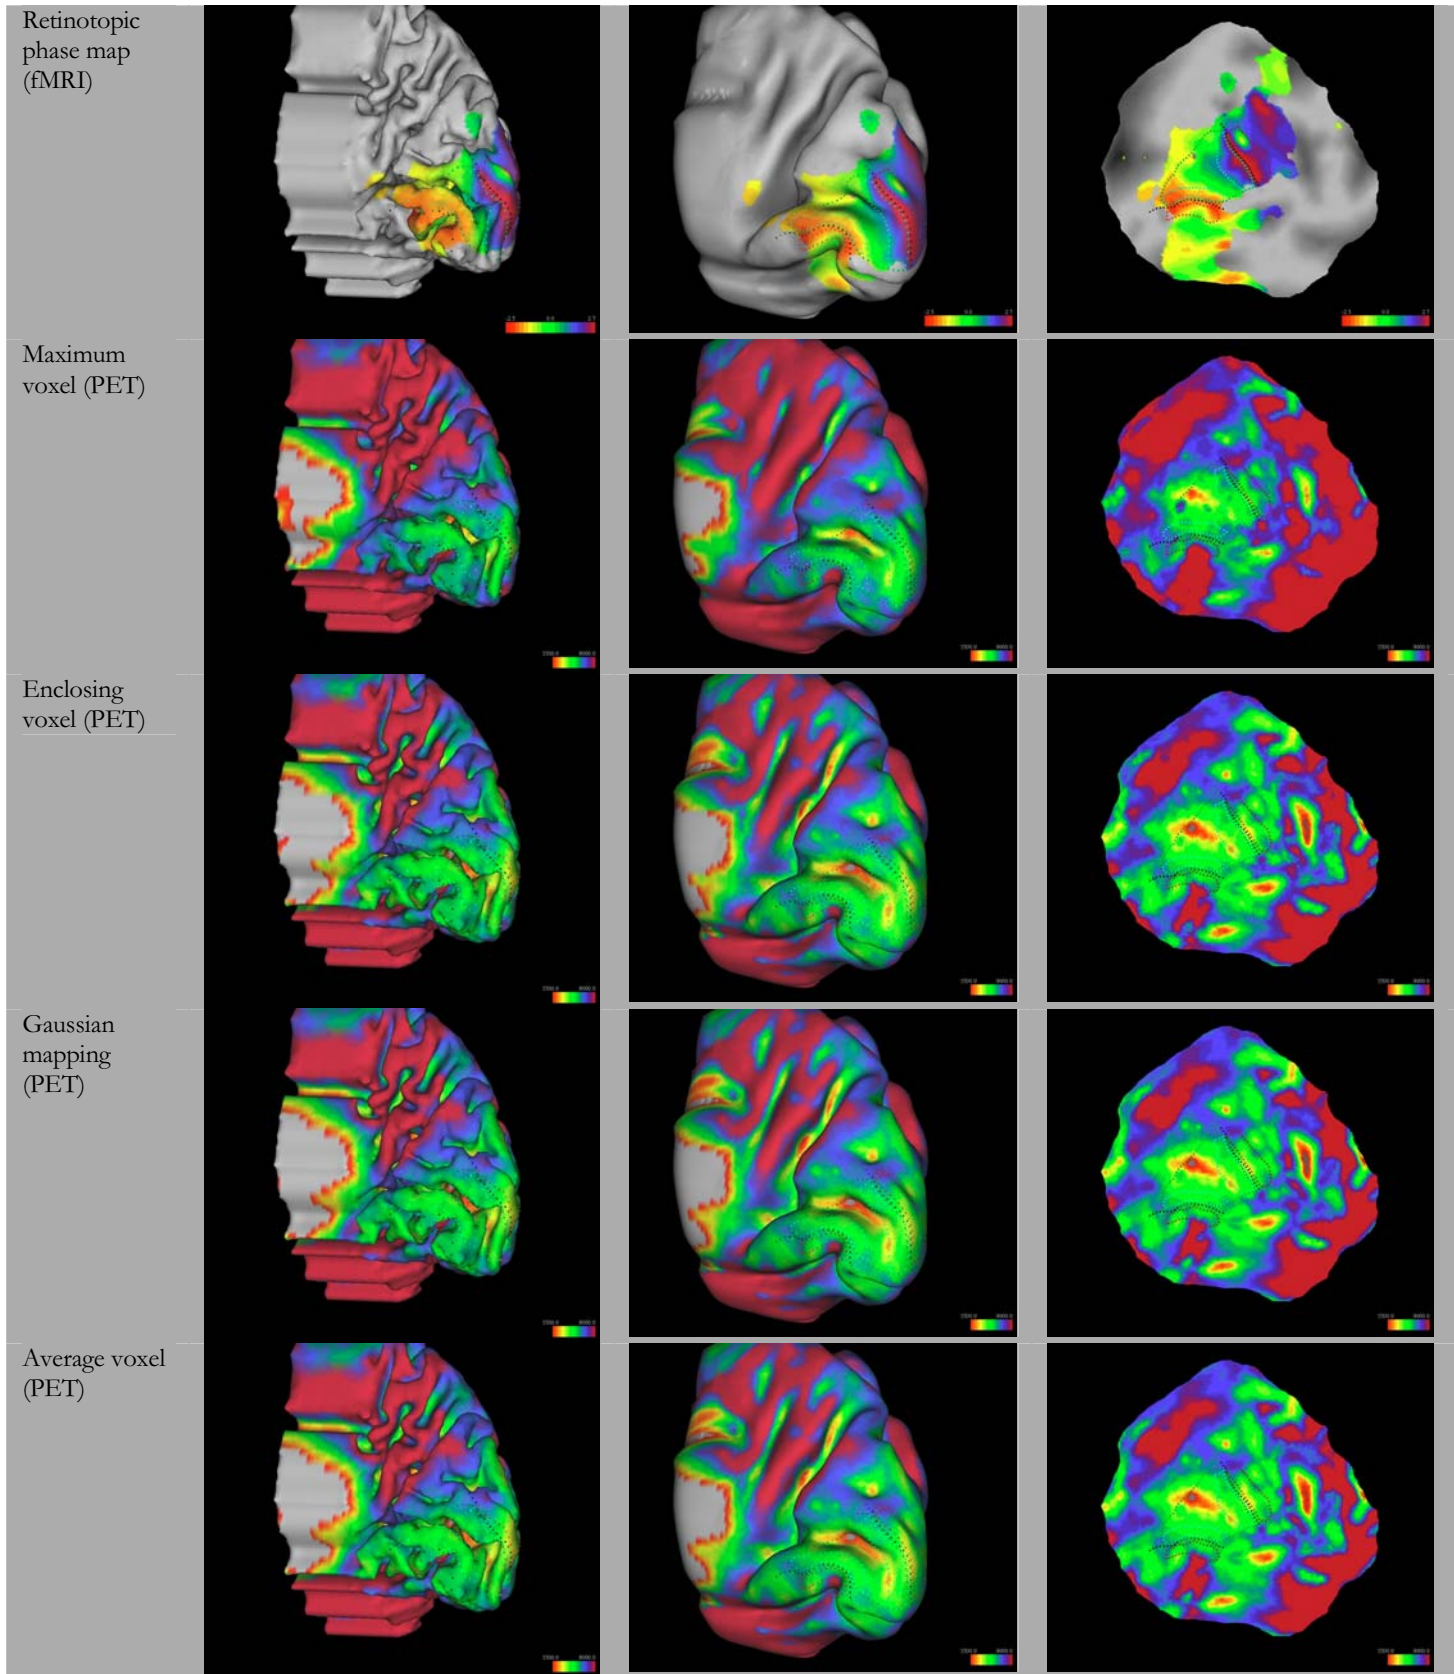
Functional data of one subject mapped on surface models reconstructed from subjects structural MRI scan. Column 1 shows the fiducial surface model, column 2 an inflated display while column 3 exhibits the according flattened representation.
